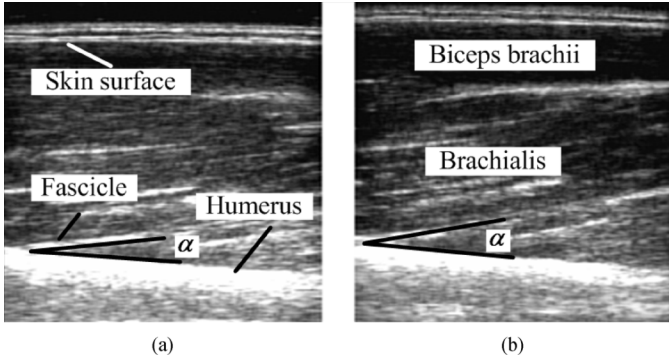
Pennation angle of brachialis in ultrasound images. The angle between two black lines is the pennation angle. (a) The image taken at the moment before contraction and (b) the image taken when the torque reached MVC.
